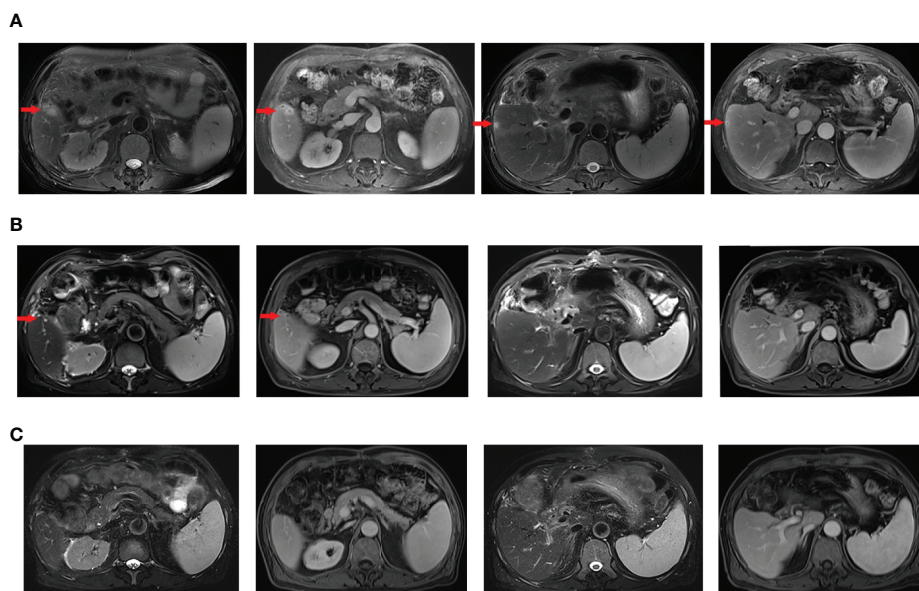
Enhanced abdominal magnetic resonance imaging (MRI) of the reported case. (A) T2-weighted and arterial phase images of liver metastasis before camrelizumab combined with apatinib (November 6, 2020). The red arrows direct to the recurrent lesions in the liver. (B) MRI showed a partial response in liver metastasis from T2-weighted and arterial phase images after 2 cycles of combination therapy (December 22, 2020). The mass (arrow) adjacent to the surgical zone decreased to 0.6 cm in the maximum diameter (1.1 cm before treatment). The lesion under the liver capsule of S5 disappeared. (C) MRI showed that lesions in the liver completely disappeared after 4 cycles of combination therapy (February 1, 2021).
